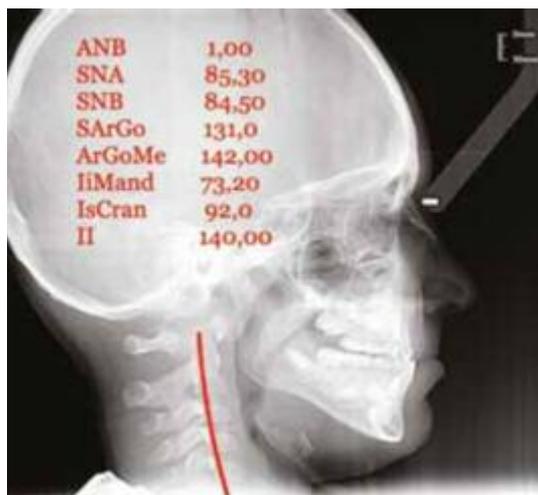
Initial radiography with evident inversion of the cervical curve
